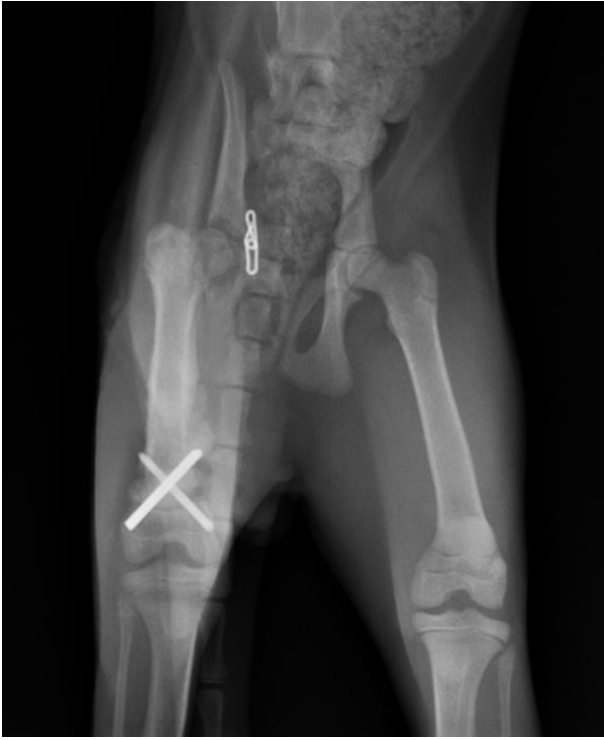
Postoperative 3rd week VD radiograph
